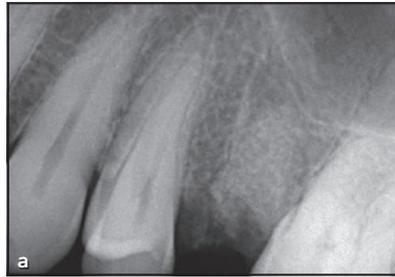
(a) Intraoral radiograph showing the alveolus at the end of the surgical procedure. The lamina dura is visible, and the socket appears to be filled with the dentin particles. The socket is sealed with a connective tissue graft. (b) Cone beam computed tomography evaluation at the end of the surgical procedure. The thin buccal plate can be noted.
